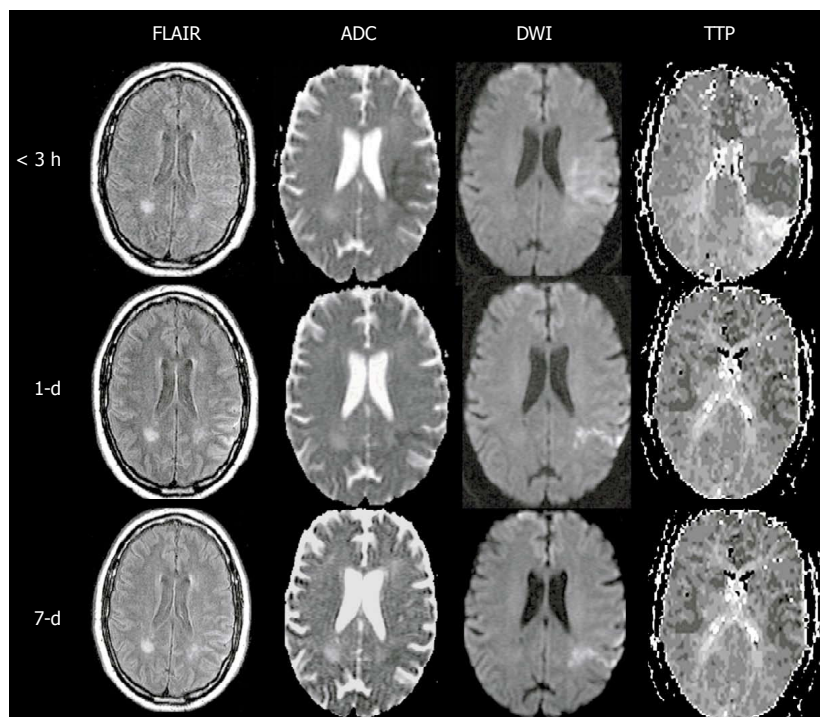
Main pattern of perfusion-diffusion mismatch, perfusion-weighted imaging = diffusion-weighted imaging, in a patient with acute stroke. < 3 h: Fuzzy diffusion-weighted imaging (DWI) lesion in left middle cerebral artery territory matching an area of diminished time to peak, indicating local hyperperfusion and spontaneous recanalization had occurred prior to imaging at 3 h after onset (note the prolonged time to peak at the posterior edge of the DWI lesion, suggesting distal branch occlusion); 1-d: The next day, perfusion has essentially normalized as well as the DWI lesion, save for a narrow posterior streak, suggesting the spontaneous recanalization saved the at-risk tissue from progressing to infarction; 7-d: At day 7, there has been no return of the DWI lesion, indicating the tissue was effectively salvaged (reprint from Muir KW *et al Lancet Neurol* 2006; 5: 755-768 with permission). PWI: Perfusion-weighted imaging; ADC: Apparent diffusion coefficient; TTP: Time to peak; FLAIR: Fluid-attenuated inversion-recovery.
